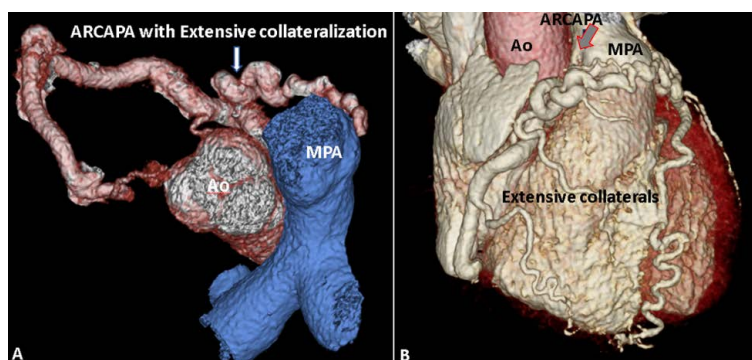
CT Images for Case 2: A and B showing ARCAPA with extensive collateralization. (ARCAPA = Anomalous origin of the right coronary artery from the pulmonary artery; MPA = main pulmonary artery; Ao = Aorta)
